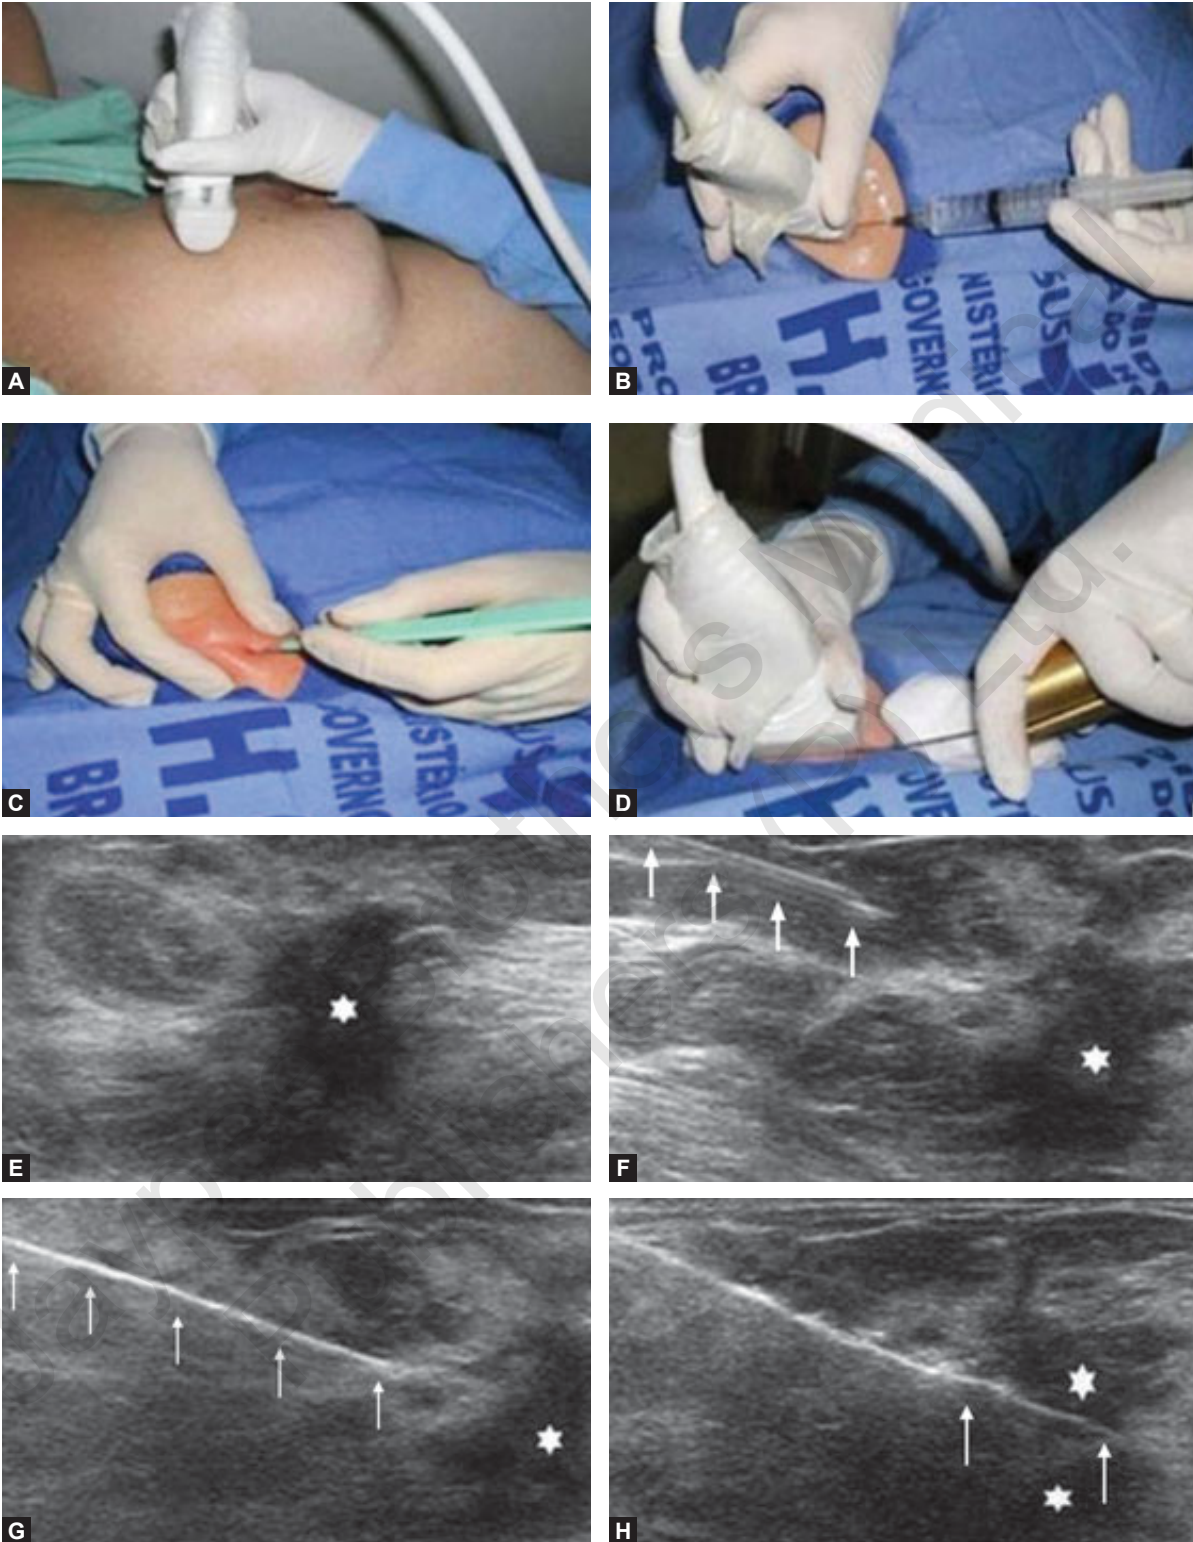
Main steps of ultrasonography-guided core biopsy of breast. A and E, Identification of the suspicious lesion (asterisk); B and F, Infiltration of the anesthetic though the pathway up to the lesion. The anesthetic needle is visualized as a fine hyperechogenic line (wide arrows); C, 2–3 mm incision on the numbed area; D and G, Through the incision, the same pathway utilized for anesthesia is utilized for insertion of the core needle (thin arrows) up to the lesion border; H, Once the core biopsy device is triggered, one must check whether the needle penetrated the lesion (asterisks). It is possible to observe the segment of the needle which advanced over the nodule (space between arrows).
